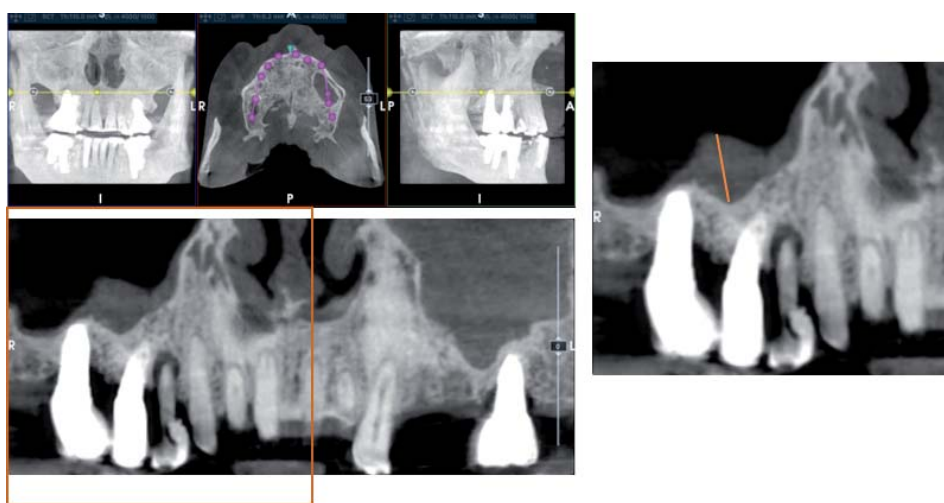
IIA CLASS: Mucosal thickening >2 mm <5 mm CBCT of a patient. The arrow indicates the maximum mucosal thickness. The mucosa is considered adequate for sinus lift so there is no need for treatment.
